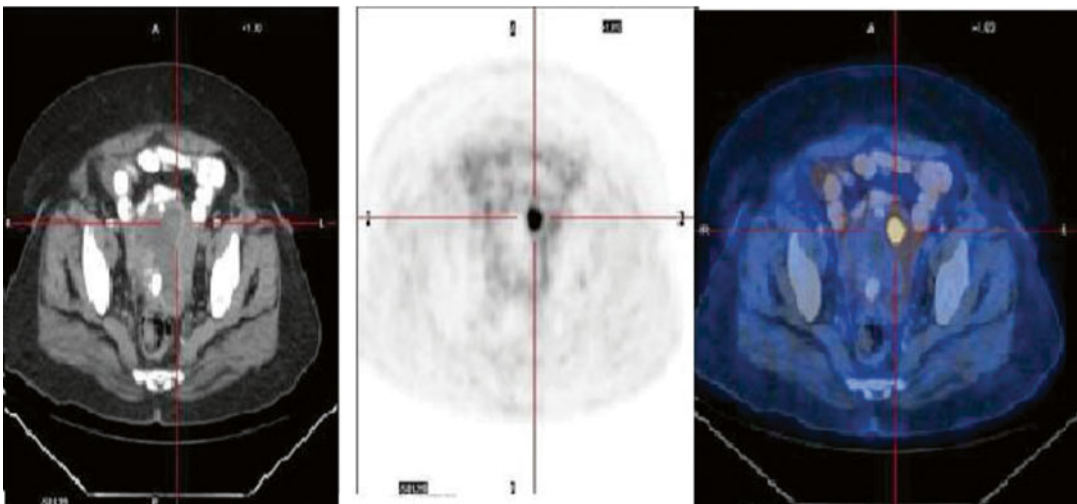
(a) Axial CT sections showing thickened heterogeneous endometrium with soft tissue area at the marked site. (b) Axial PET images showing FDG-avid
